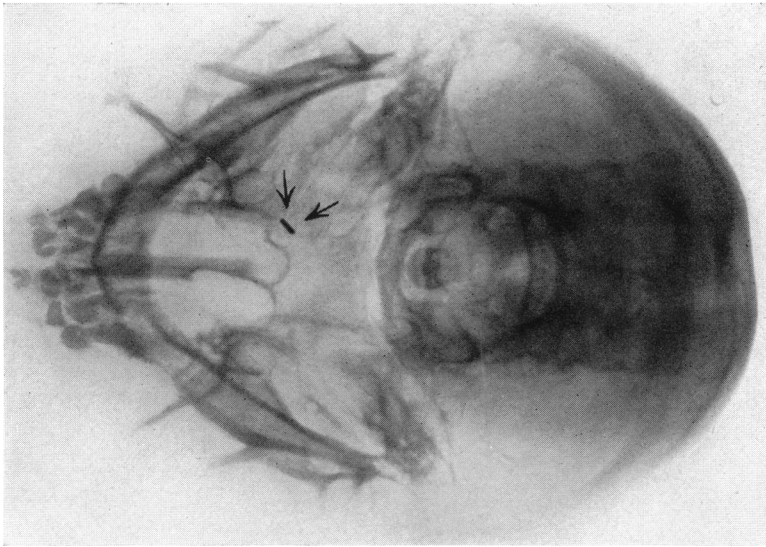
Roentgenogram of the base of the skull showing the position of the silver clip placed upon the neck of the aneurysm.
